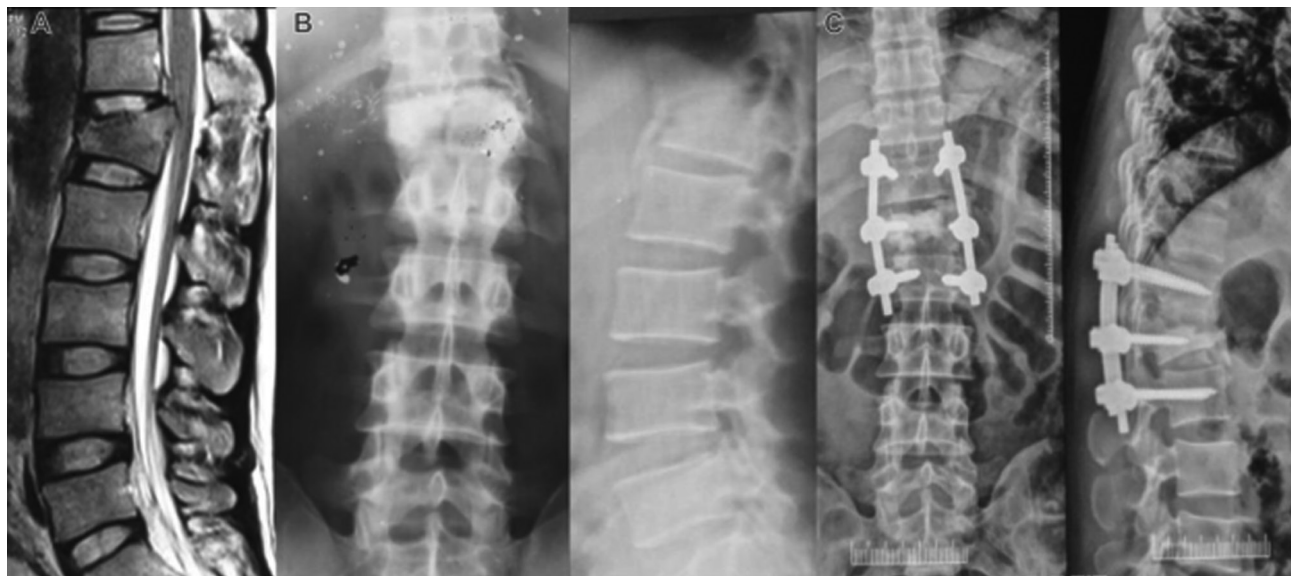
Short-segment fixation including fracture segment (SSF IFS): (A) Preoperative magnetic resonance imaging, (B) preoperative X-ray, and (C) postoperative SSF IFS.
